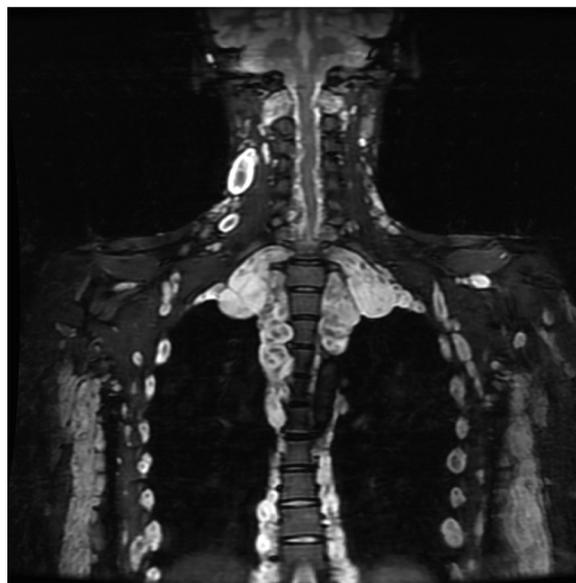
Coronal STIR MRI of the neck shows undulation of the cervical cord due to intradural extension of the segmental neurofibromas. Extensive internal tumour burden is evident in this spinal variant.
